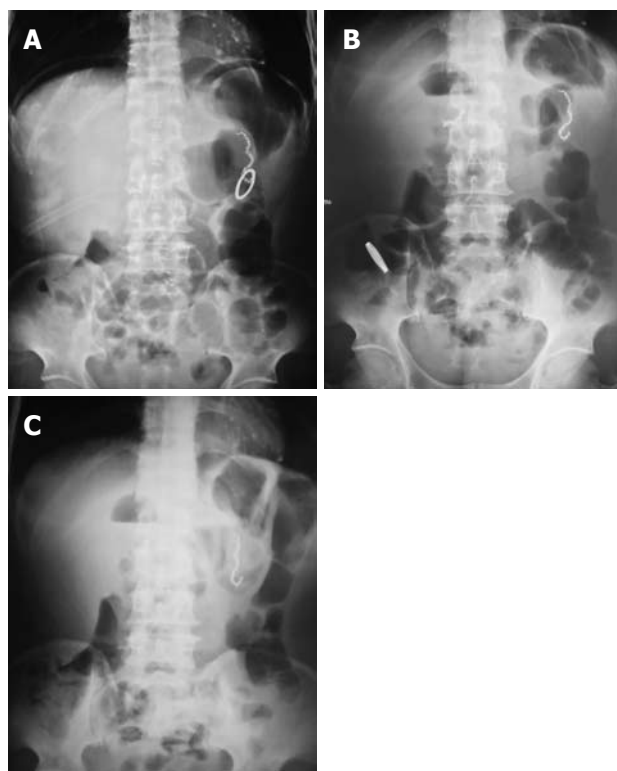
Plain X-ray film showing the CAC *in situ* in abdomen of patients who underwent radical resection of gastric cancer and Billroth II reconstruction 5 d after operation (A), the ring moving to the right lower abdomen 11 d after operation (B), and expelling of the ring with stools 15 d after operation (C).
